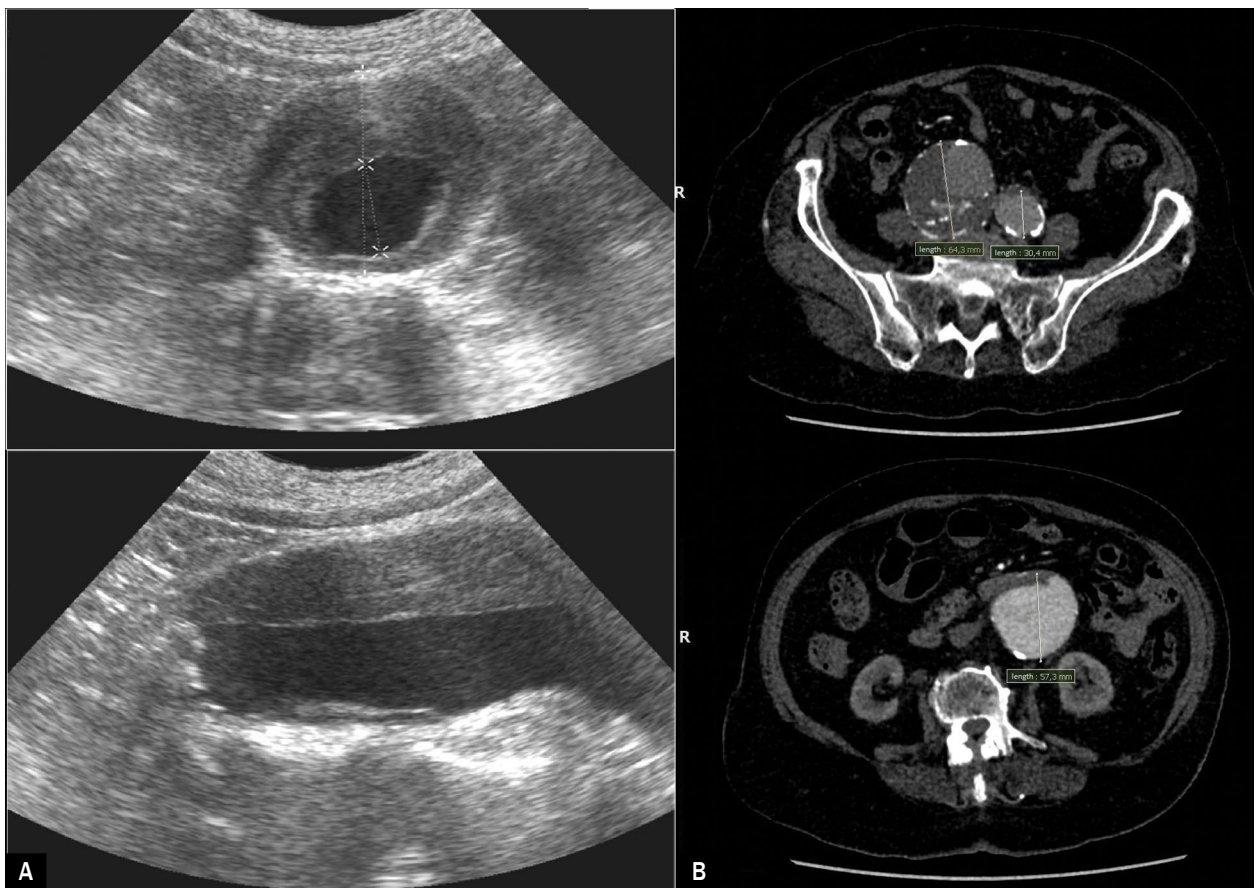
Abdominal aortic aneurysm with haemorrhagic thrombus (A – ultrasound; B – computed tomography angiogram) and right iliac aneurysm with a large thrombus with deep ulceration (B – computed tomography angiogram)
